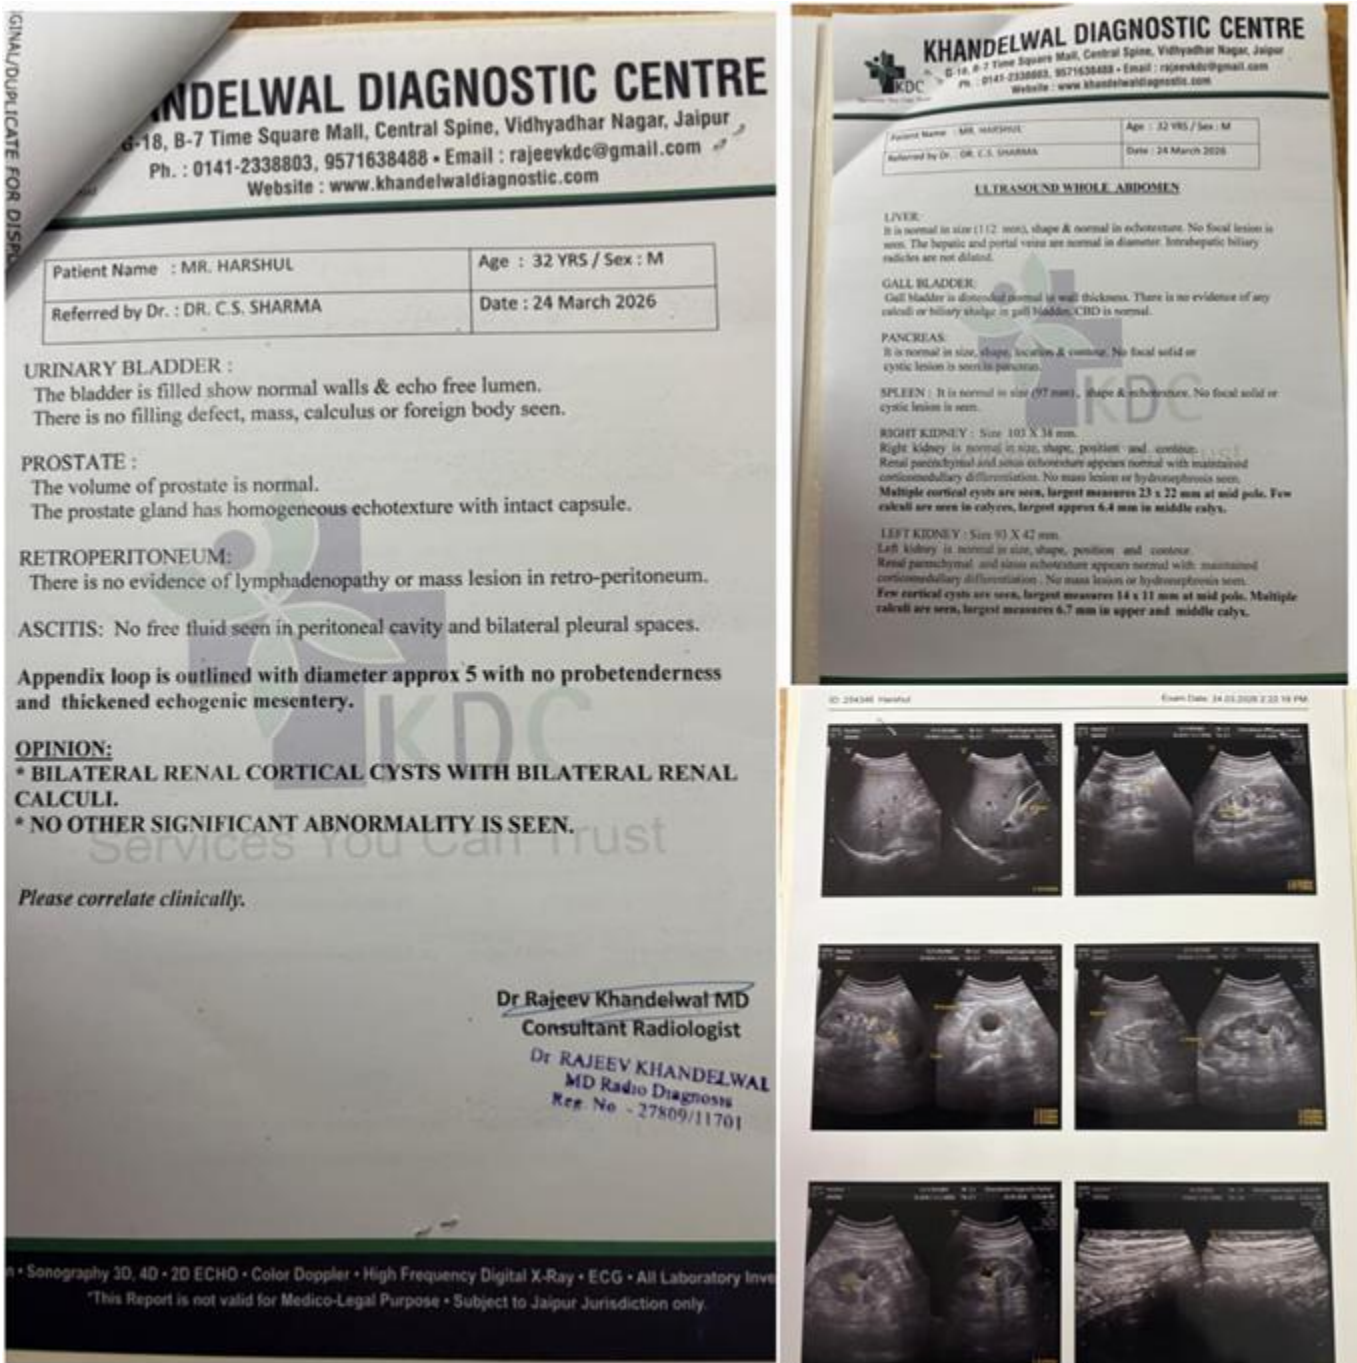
Final abdominal ultrasonography (24 March 2026) showing normal appendix (~5 mm diameter) with complete resolution of inflammation.
